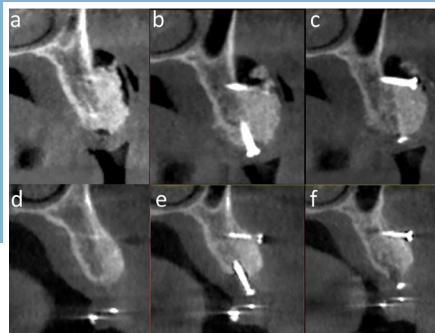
Comparison of CBCT postoperatively (a,b,c) and 6 months after regeneration (d,e,f). It is possible to note the limited resorption of the graft and its perfect integration with the native bone.
